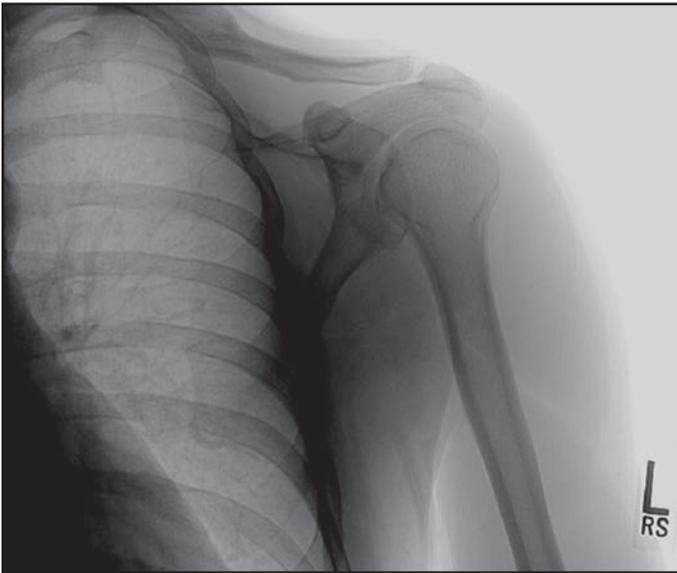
An anterior-posterior radiograph of the shoulder. Note the prominence of the lesser tuberosity near the glenohumeral joint line.
